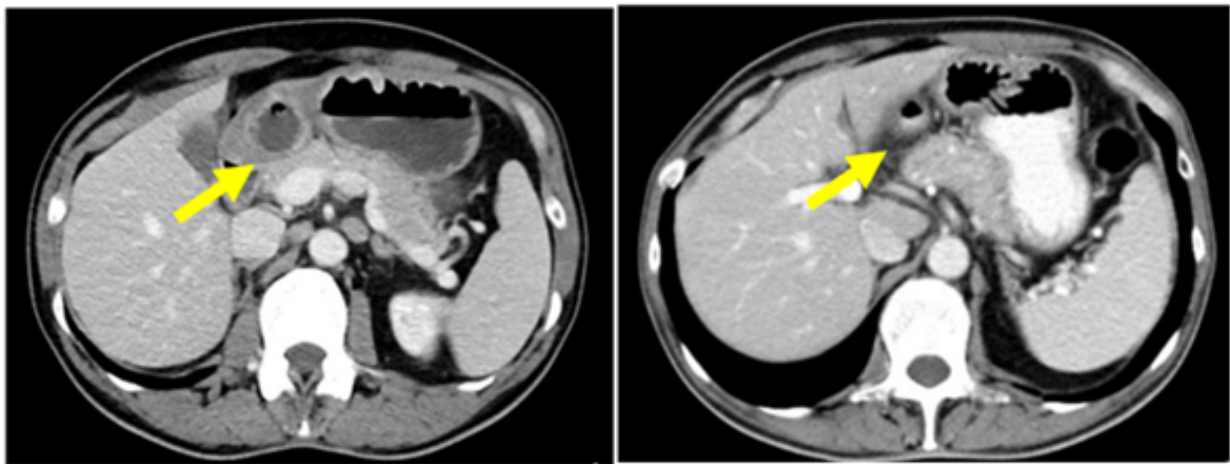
Contrast-enhanced abdominal computed tomography images obtained approximately 6 months apart (9 March 2022 on the left and 2 August 2022 on the right), showing marked interval regression of the previously described distal gastric wall thickening involving the gastric body/antrum and pylorus following treatment.
